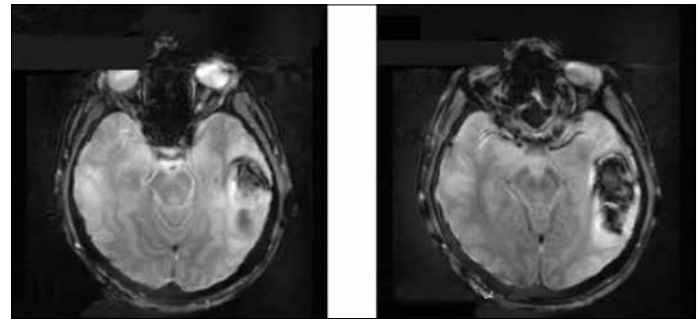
Intratumoral hemorrhage in the left temporoparietal lobe on MRI
